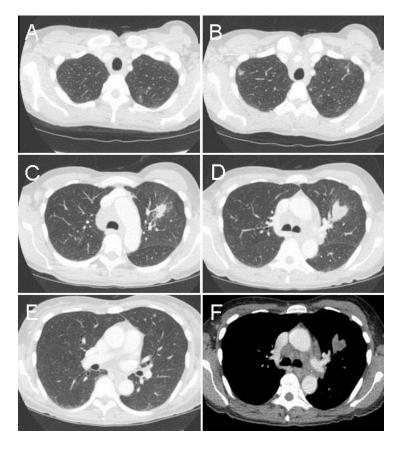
Representative images from the thoracic CT scan in lung windows (A-E) and soft tissue windows (F).
